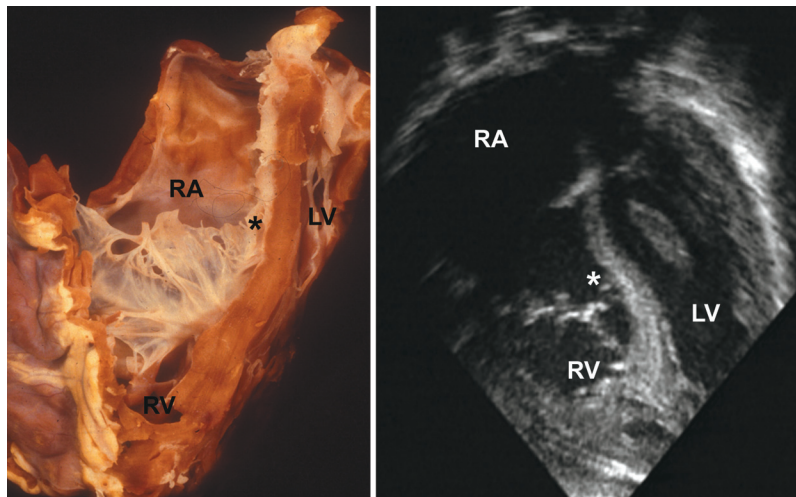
Apical four-chamber view of an Ebstein malformation of the tricuspid valve. Note the significant displacement of the septal tricuspid valve leaflet (asterisk) with associated valve dysplasia. LV = left ventricle; RA = right atrium; RV = right ventricle.
